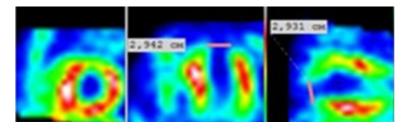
The tomoscintigraphy image of the myocardium after surgery.
